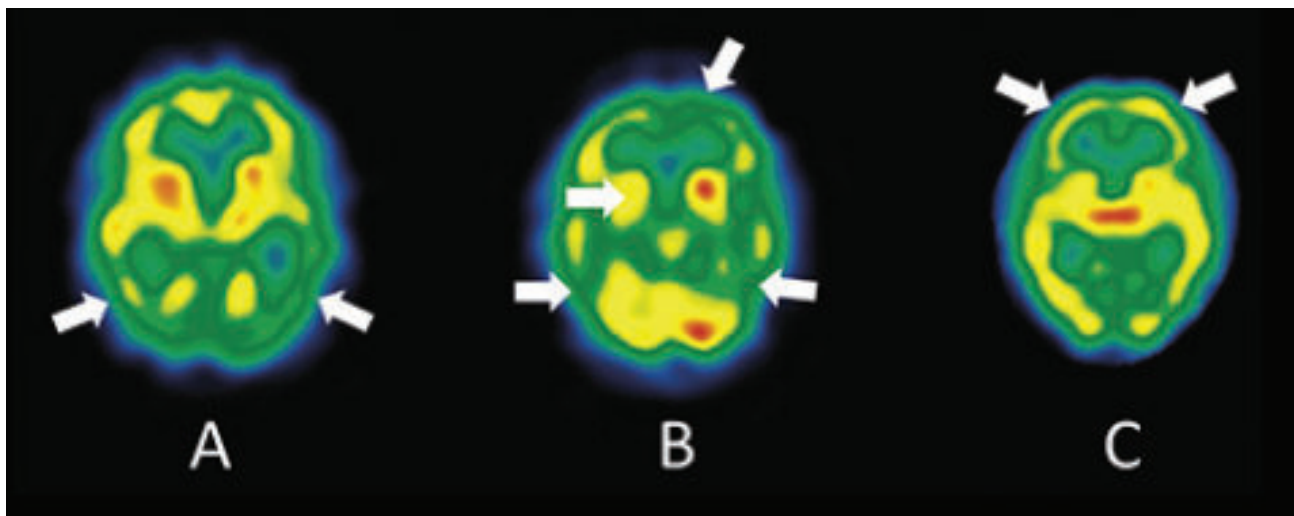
Tc-99m HMPAO SPECT scans in 3 patients with dementia showing perfusion patterns suggestive of Alzheimer’s disease, with bilateral temporo-parietal hypoperfusion (A), vascular dementia with multiple asymmetrical lesions affecting the anterior and posterior cortex and right striatum (B) and fronto-temporal dementia with frontal hypoperfusion (C).
